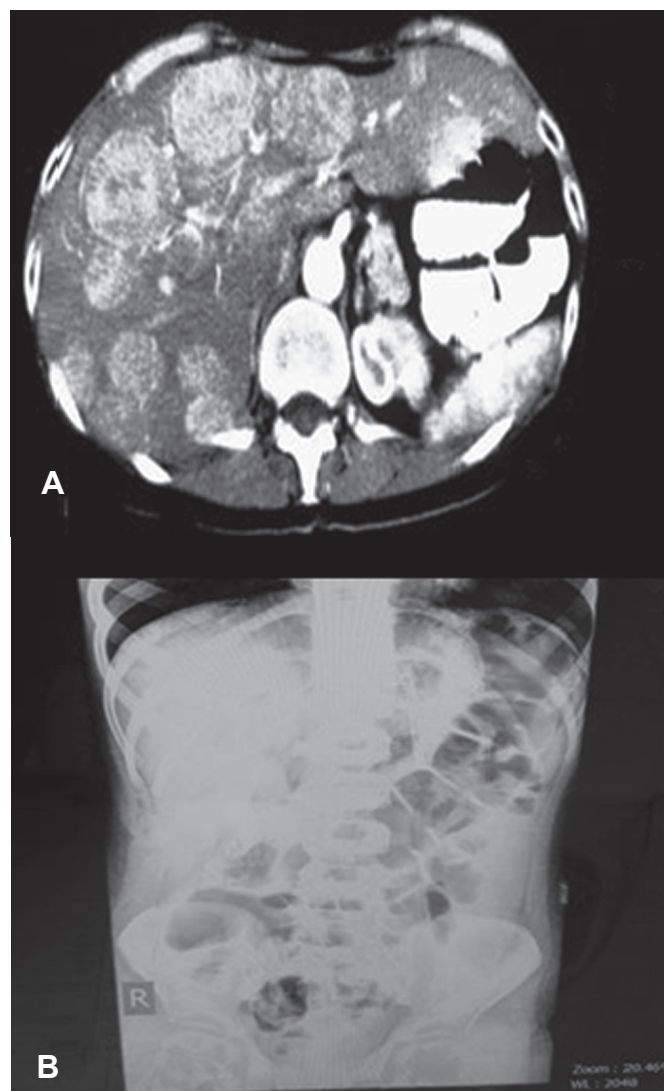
A: Abdominal computed tomography scan shows multiple homogenous parenchymal densities in the liver. B: Plain abdominal radiogram, upright.
